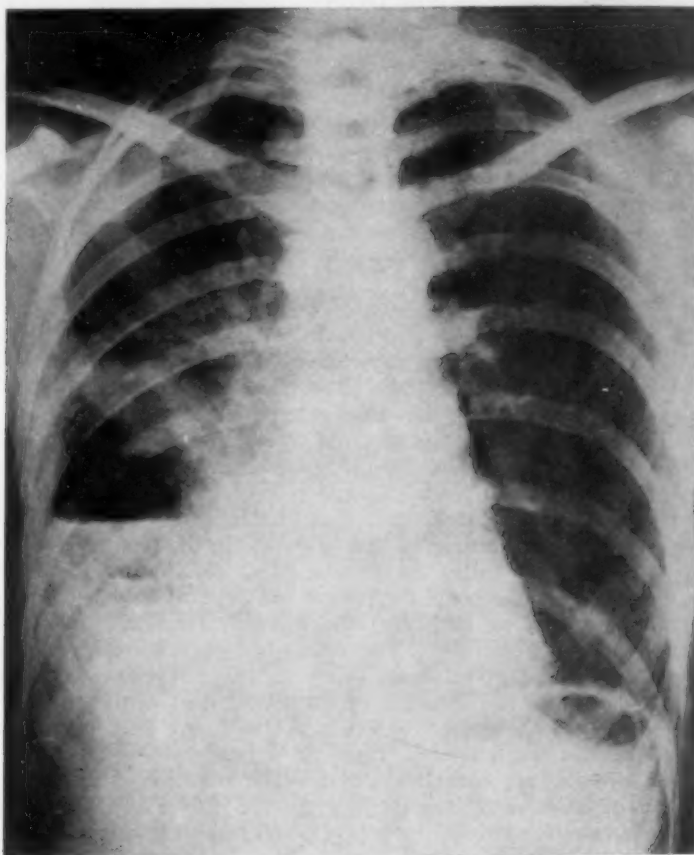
Roentgenogram of lungs taken nine days after onset of illness. A large abscess cavity is present in the right lower lobe.
